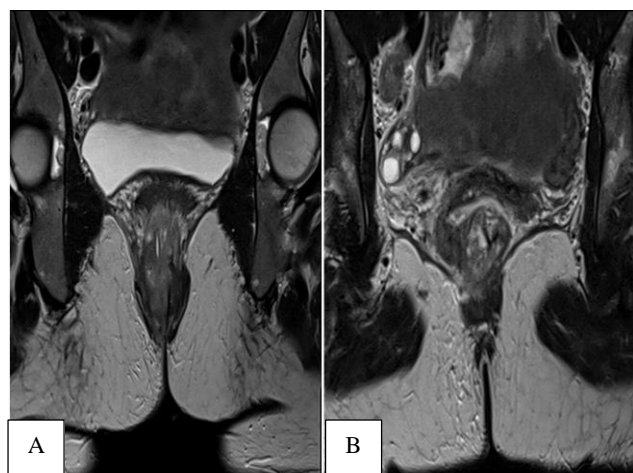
(A and B): T2 MRI coronal view of the mass shows invasion of the internal sphincter complex.
